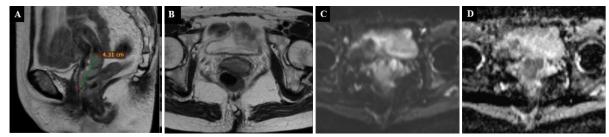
Pelvic MRI Examination of Case 6
